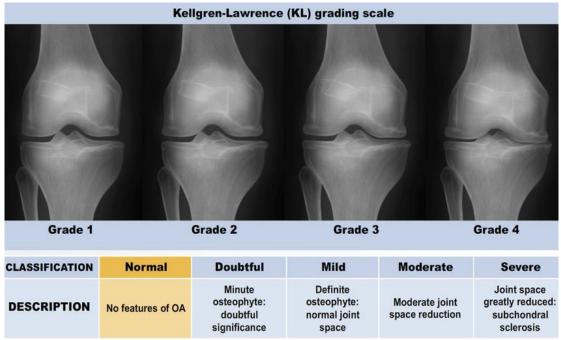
Knee X-Ray of Osteoarthritic Patients
